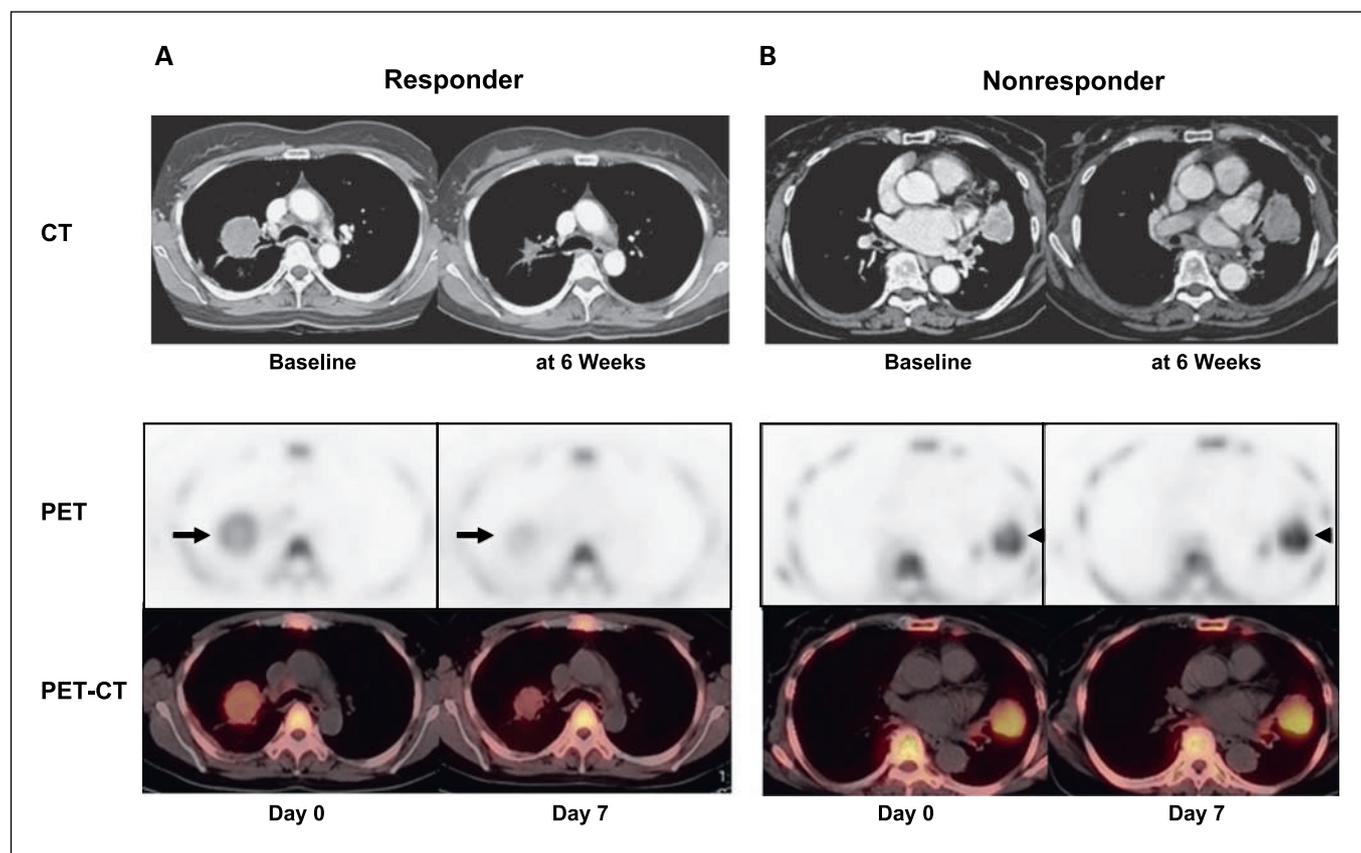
PET images of a patient (A) show markedly decreased FLT uptake (SUVmax = 4.8 → 2.3) at 7 d after gefitinib therapy. The subsequent CT scan at 6 wk reveals tumor shrinkage. PET images of another patient (B) show no visible change at 7 days after gefitinib therapy (SUVmax = 7.2 → 8.0) and increase in tumor size at 6 wk.
